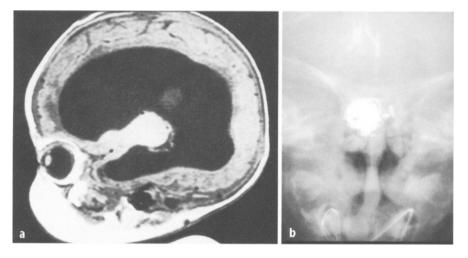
GDC coil treatment of PICA aneurysm in an Infant. a Aneurysm before treatment. b Plain skull x-ray showing aneurysm packed with coils
